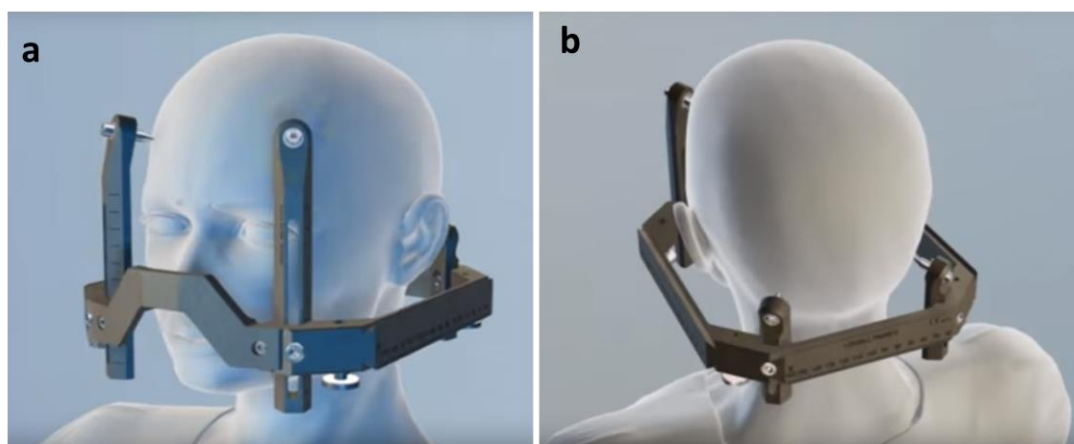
The minimally invasive Leksell stereotactic frame is firmly fixed on the patient using the four pins, prior to MR image acquisitions. The MR indicator box should also be fixed (not shown here). Images taken from [Elekta official youtube channel].
